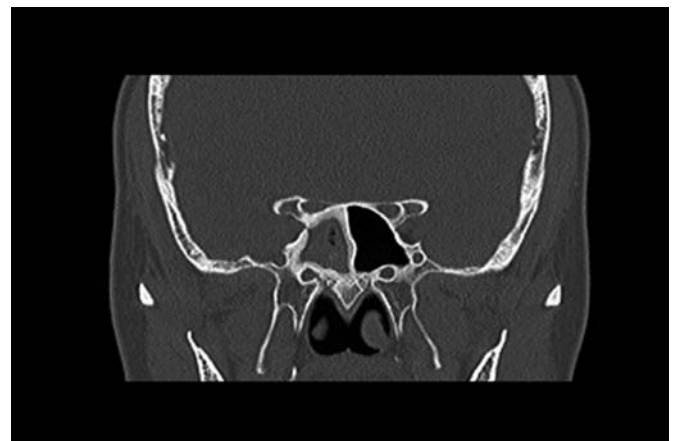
Coronal paranasal sinus computed tomography showing right sphenoid sinus heterogeneous opacification, and bone thickening of the sinus wall.
